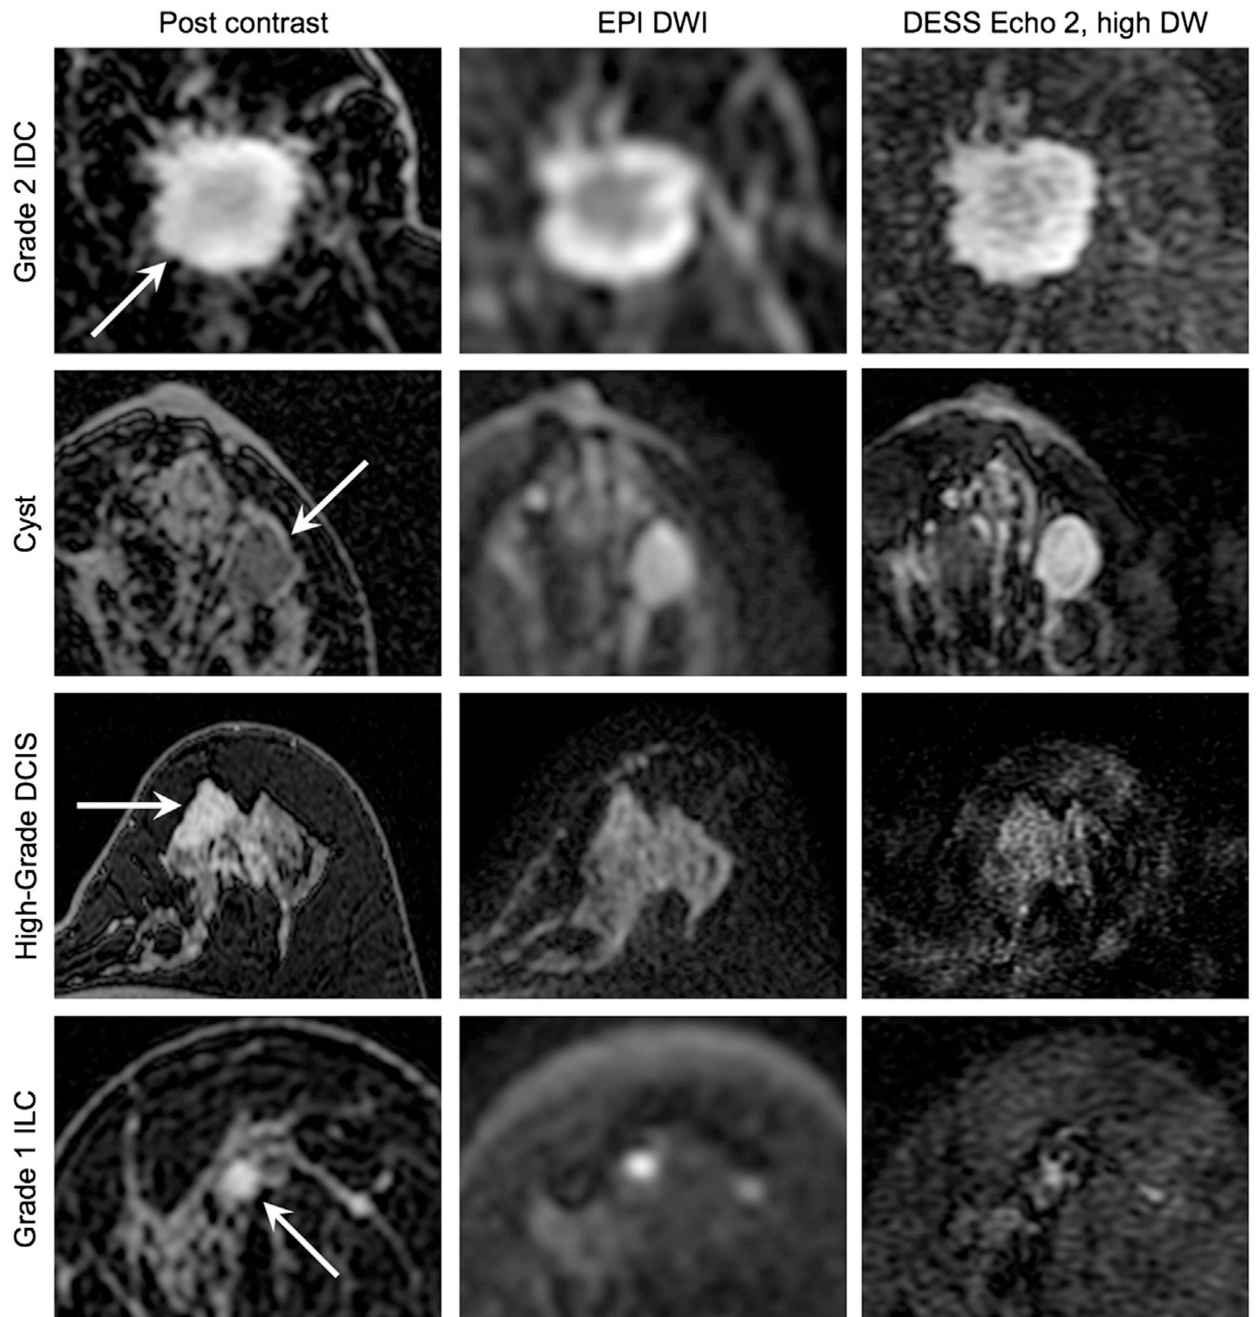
In vivo diffusion attenuation comparison. Typical patient images depicting an invasive ductal carcinoma (IDC), a benign cyst, a high-grade ductal carcinoma in situ (DCIS), and an invasive lobular carcinoma (ILC) acquired with contrast-enhanced T1 weighting (Post contrast) and diffusion weighting. The DESS images show higher resolution and less distortion than the conventional spin-echo EPI diffusion-weighted images (DWI), but with comparable image contrast.
